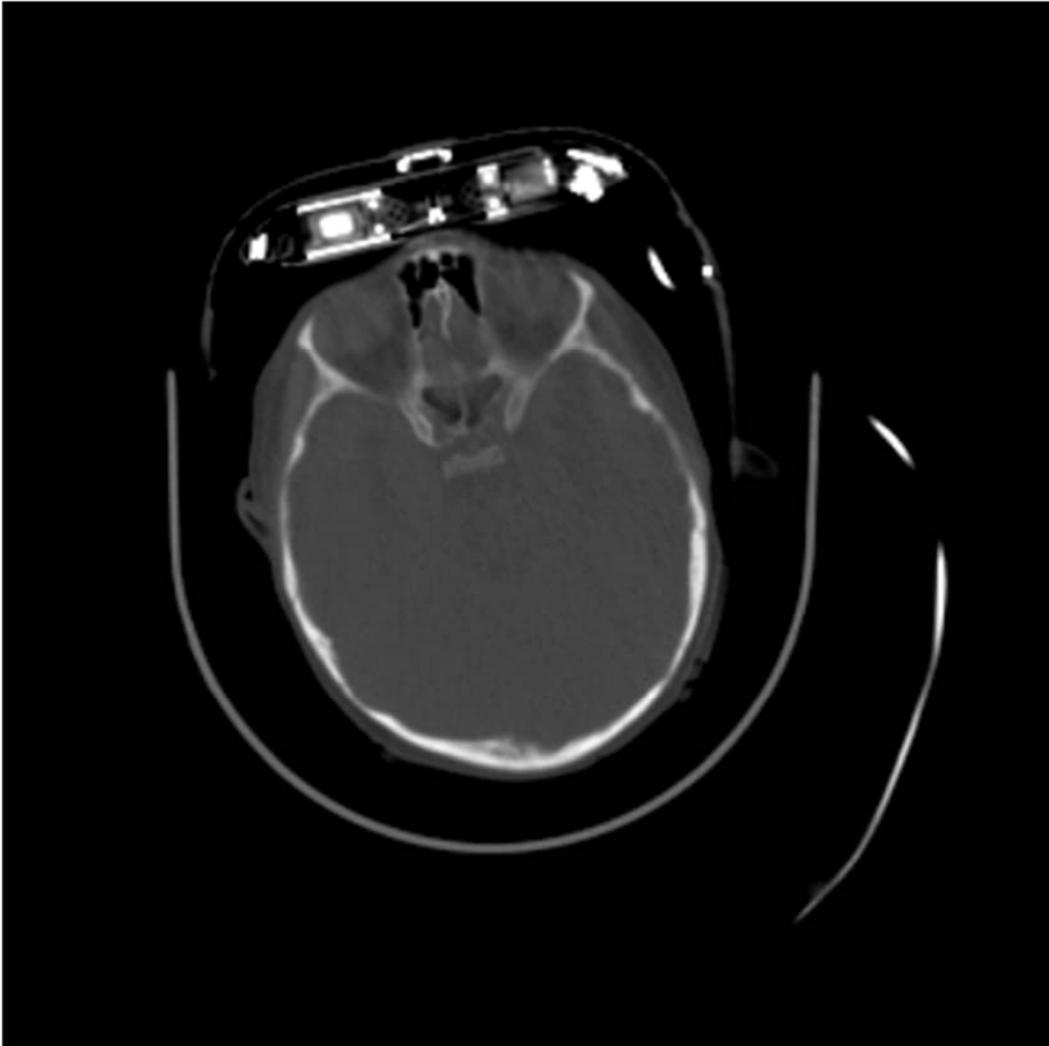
The adjacent axial CT section from the same study viewed at bone windows showing very mild bone artifact.
